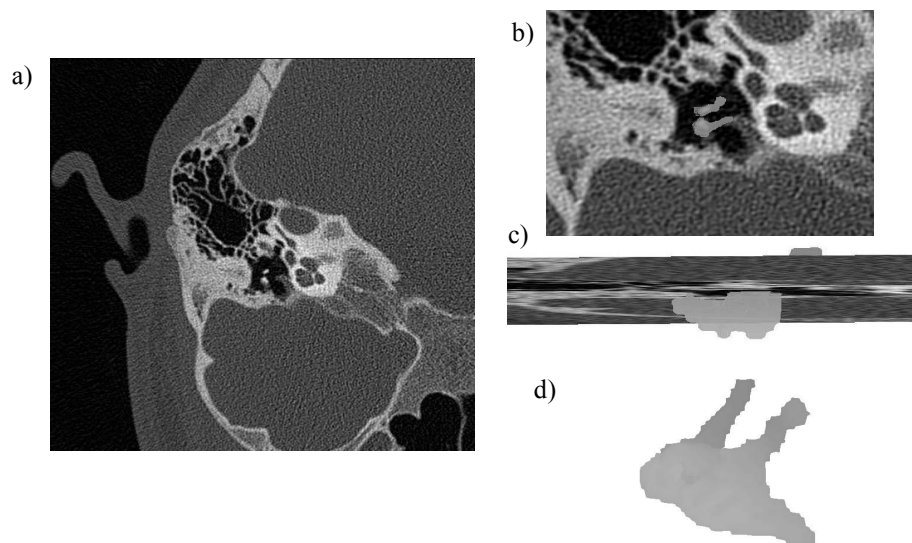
a) Original axial CT image slice; b) Image a) zoomed and registered with an inferior view of the ossicles segmented; c) Original coronal CT image slice zoomed and registered with a superior view of the ossicles segmented; d) Ossicles segmented in 3D.
